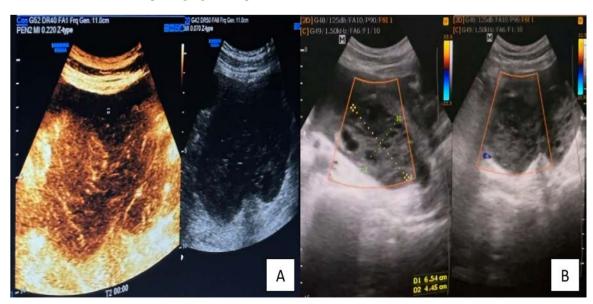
(A) Contrast enhanced ultrasound showing delayed time to peak, (B) Ultrasound of ovary showing stromal oedema
